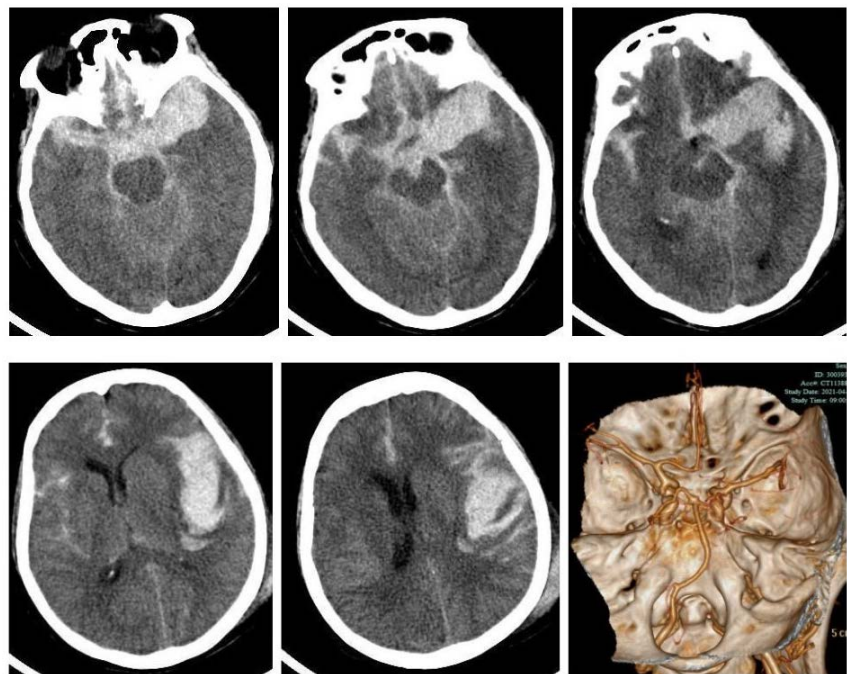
Subarachnoid hemorrhage (SAH) as well as left temporal lobe and lateral cleft hematoma. According to 3D-CTA, it indicates the left posterior communicating aneurysm.
